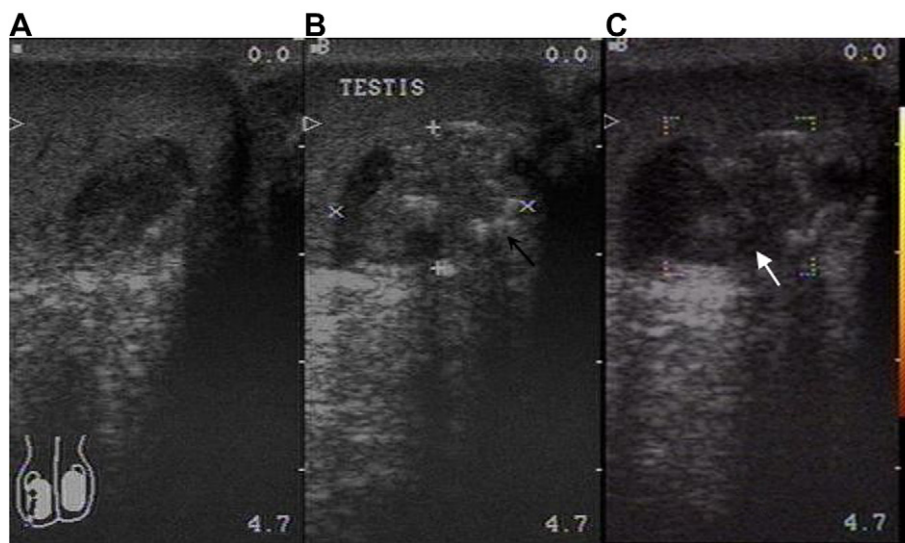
(A) A well-circumscribed heterogeneous mass (B) with an echogenic rim (black arrow). (C) Color Doppler ultrasonography reveals no vascularity within mass (white arrow).
